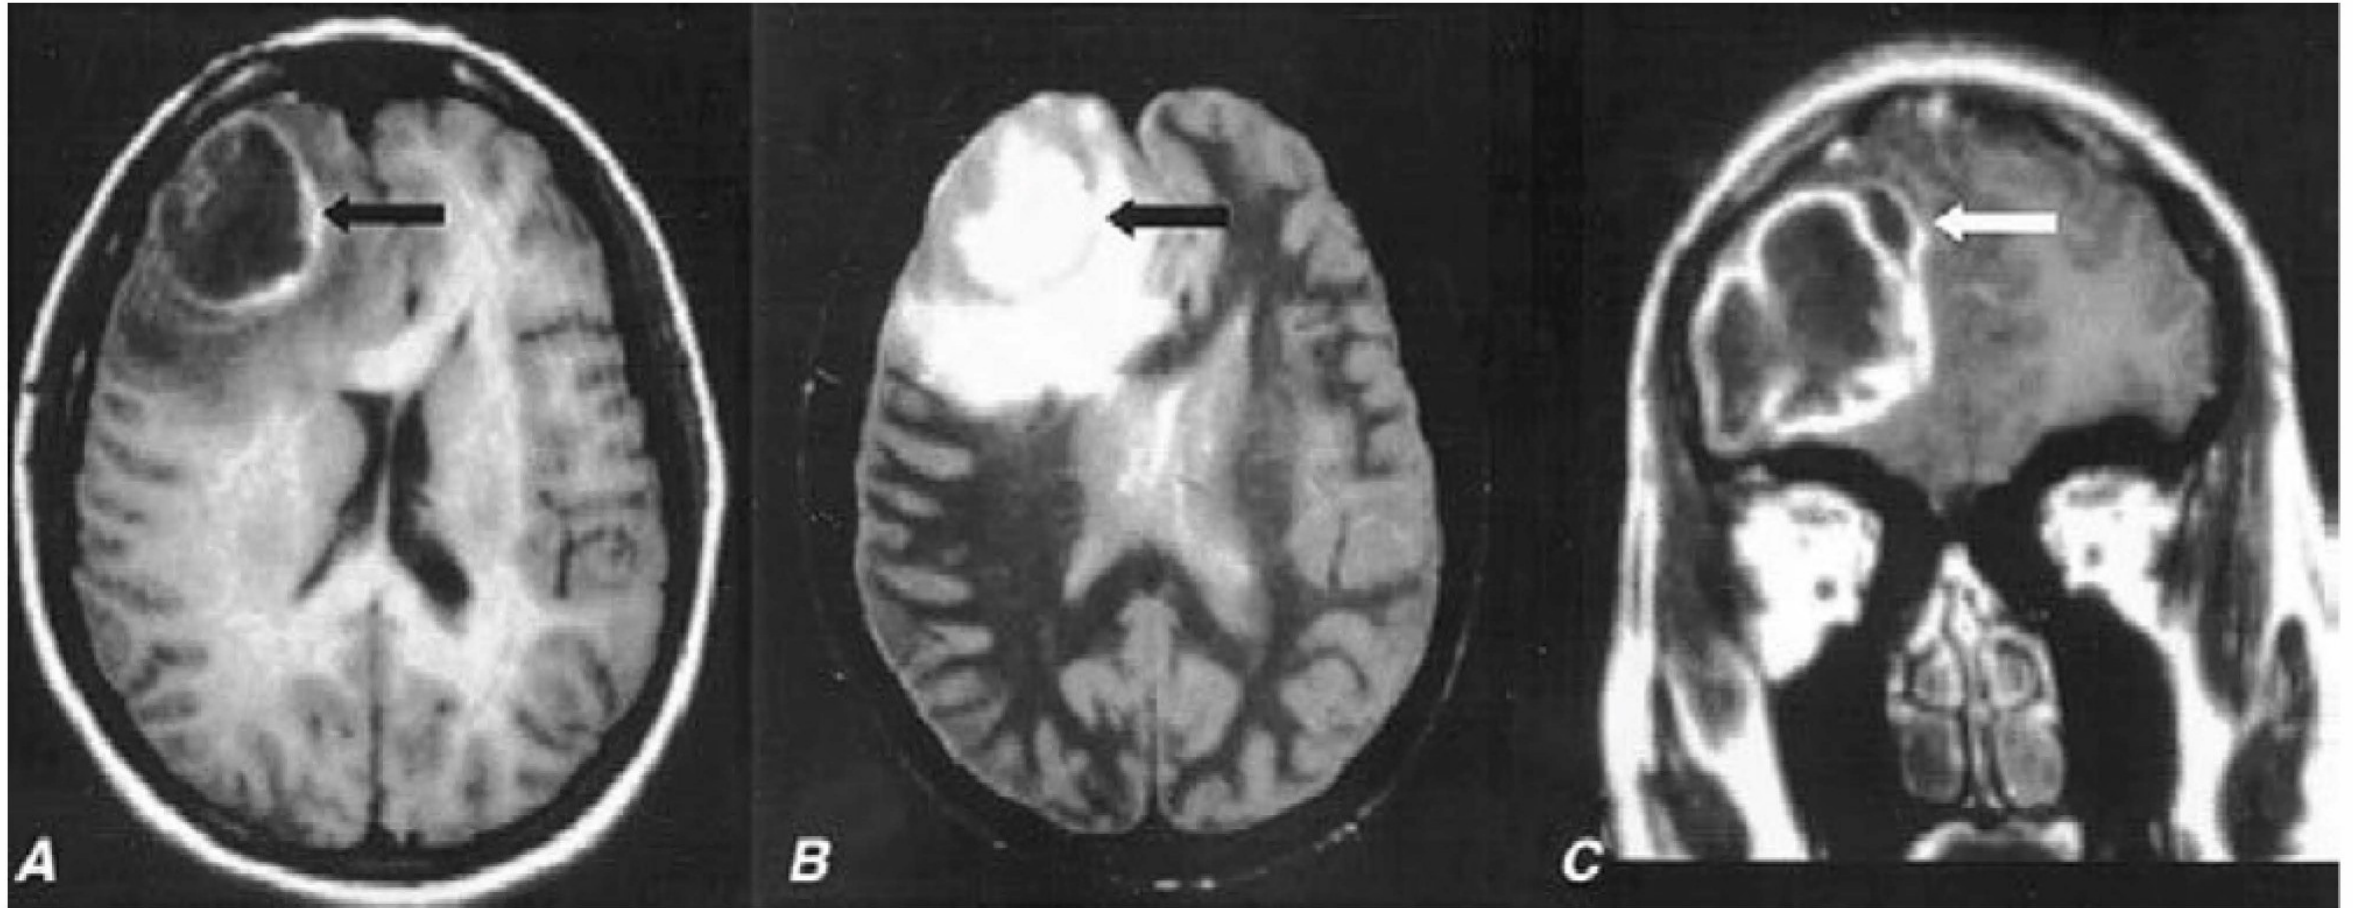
Pneumococcal brain abscess. Note that the abscess wall has hyperintense signal on the axial T1-weighted magnetic resonance imaging (MRI) (A, *black arrow*), hypointense signal on the axial proton density images (B, *black arrow*), and enhances prominently after gadolinium administration on the coronal T1-weighted image (C). The abscess is surrounded by a large amount of vasogenic edema and has a small “daughter” abscess (C, *white arrow*). (Courtesy of Joseph Lurito, MD; with permission.)
